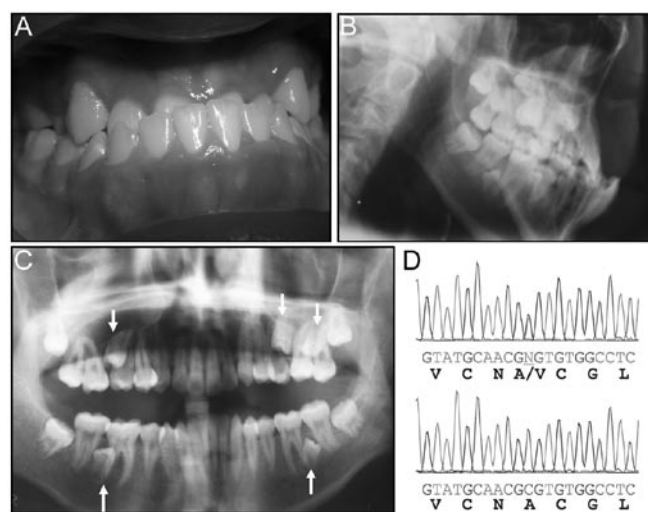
Mandibular prognathism and supernumerary teeth observed in a 17-year-old Thai male with TRPS. (A) Mandibular prognathism observed at 14 yrs old. (B) X-ray at age 17 showing a very prognathic mandible. (C) Panoramic x-ray at age 17 shows 5 non-erupted supernumerary teeth exhibiting premolar-like shape (arrows). (D) Electrophoretograms of the sequencing of PCR products. A heterozygous C>T mutation was found at nucleotide position 2756.
